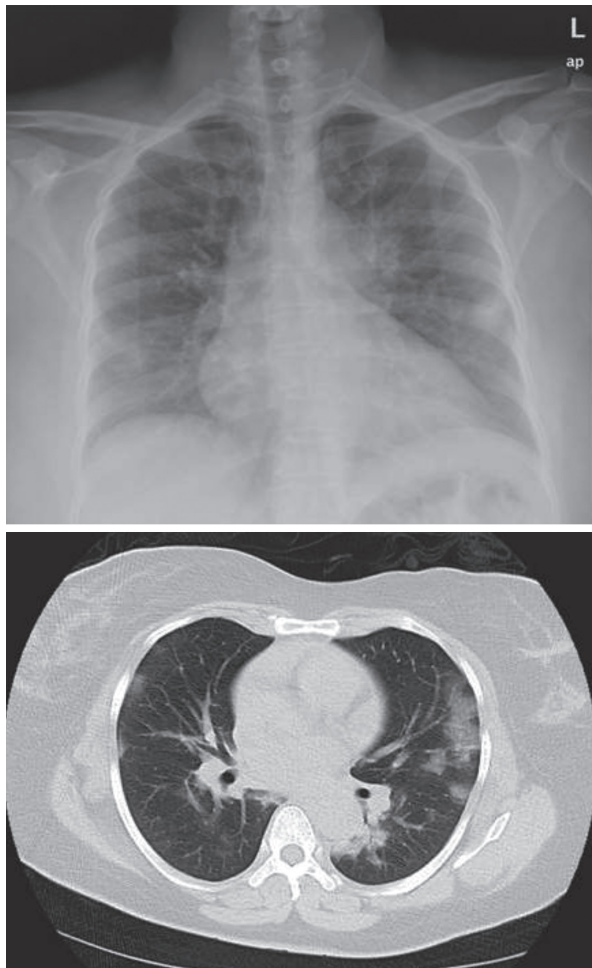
Elderly female presented with fever and diarrhea, and diagnosed with COVID-19 by RT-PCR. Top image shows an initial chest radiograph with mild ground-glass opacity in the left lung. Bottom image shows same day CT chest with corresponding opacity in the lingula.
